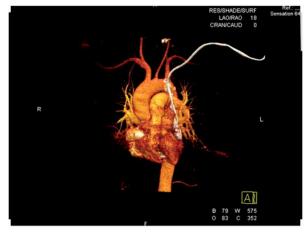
The CTA in Figure 2 depicts a more detailed view of the contrast media draining into the coronary sinus and the right atrium.
